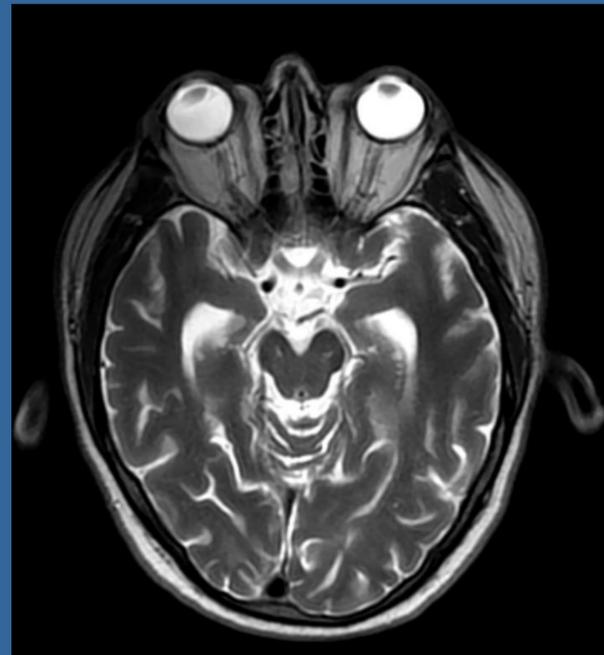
Pre-operative MRI screening (T2)
